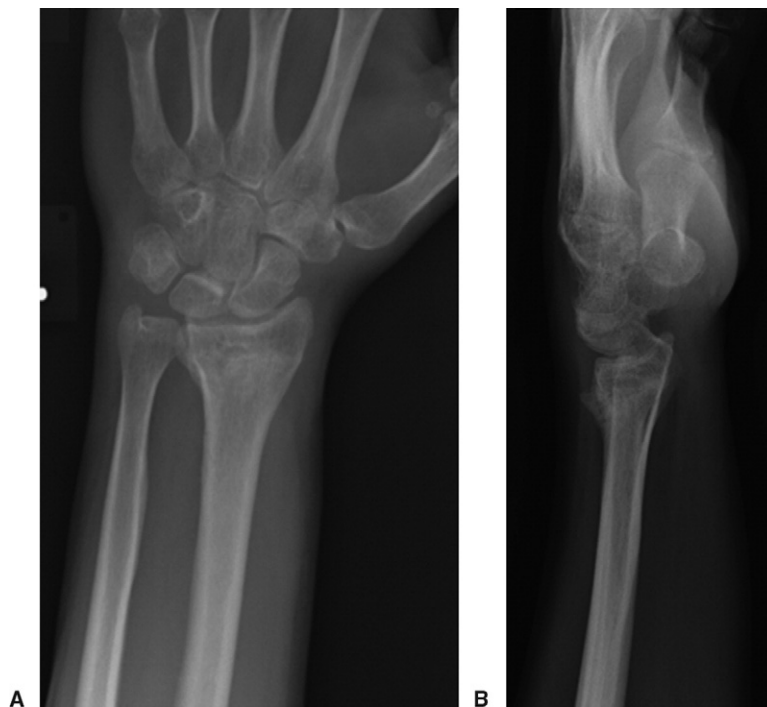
A Anteroposterior and B lateral radiographs of a 57-year-old woman who presented with pain and limited motion of her left wrist are shown 4 months after the injury. Radiographs showed 24° of dorsal tilt.
